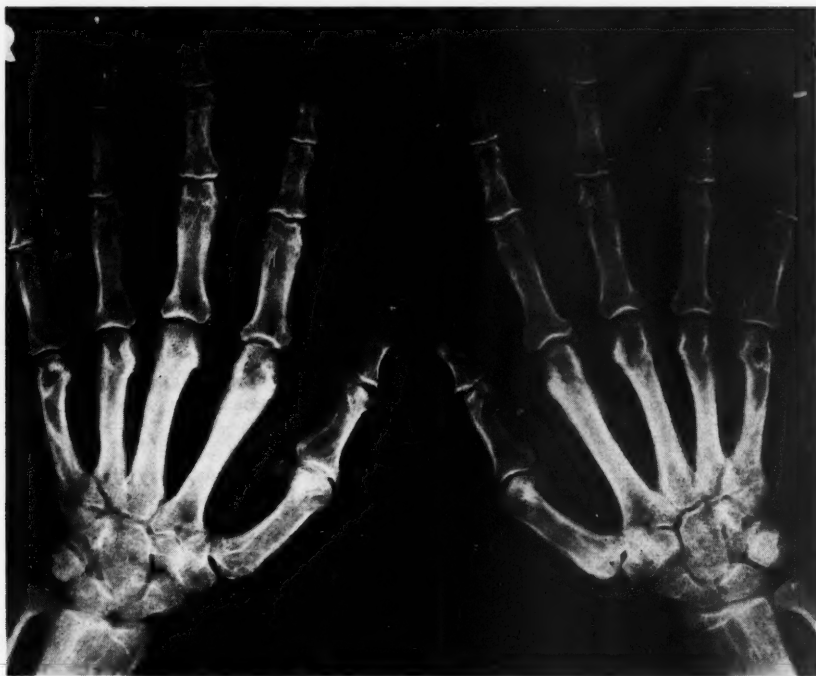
X-ray of the hands show:
